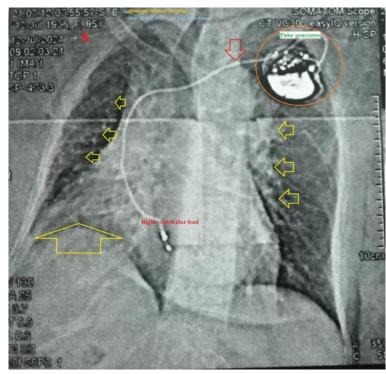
A-Plain chest X-ray section of chest CT was done on the day of the ICU presentation and within 3 days of CVA showed the position of the pacemaker (pulse generator; orange circle), electrode (RV lead, red arrow), bilateral ground-glass opacities (yellow arrows), and dysmorphic cardiac shadow.
